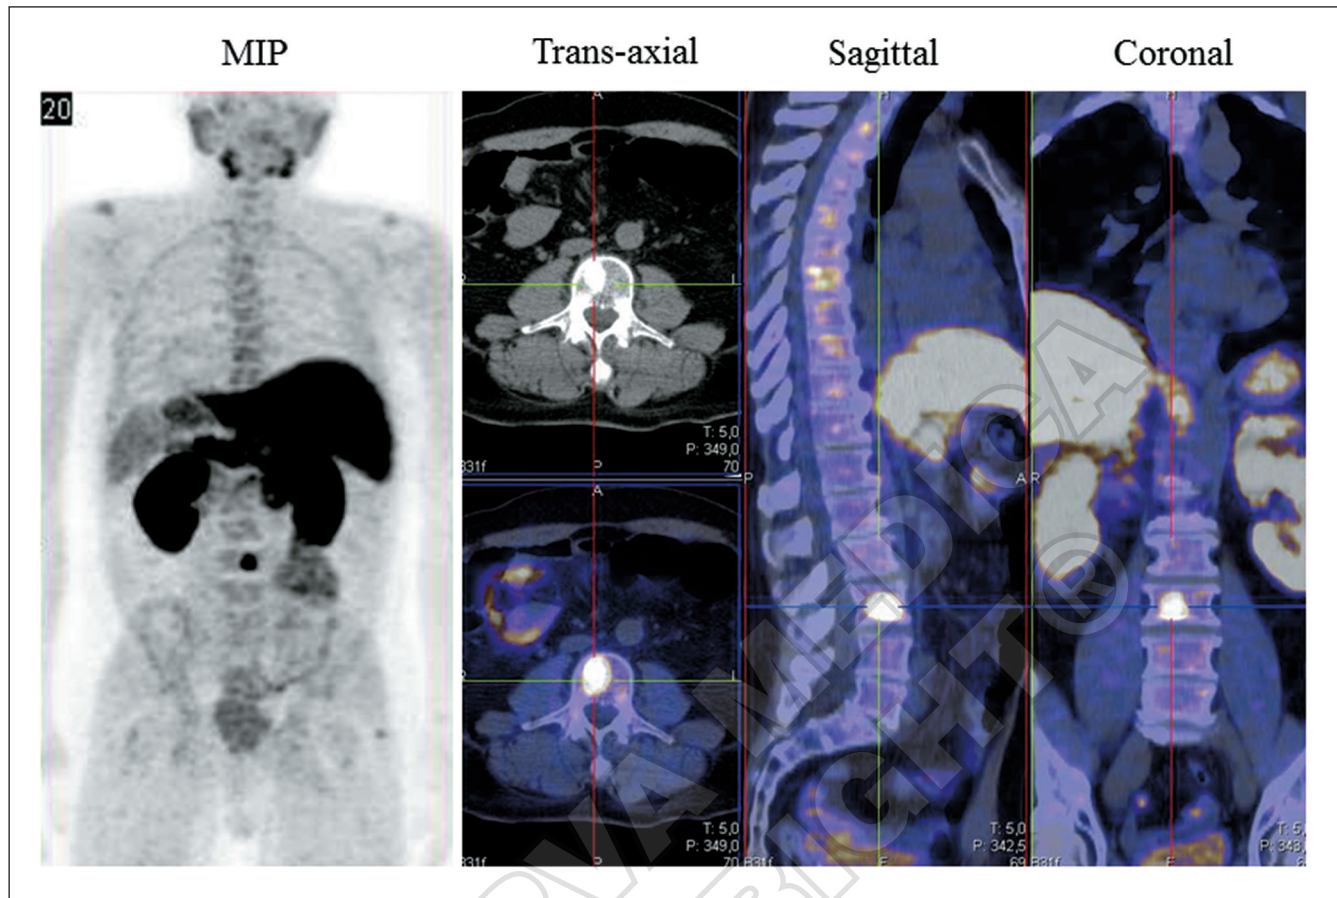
A 64-year old man with a prostate cancer (radical prostatectomy in 2008). Increase in PSA level during therapy with LH-RH analogues (0.35 ng/mL in September 2011, 0.62 ng/mL in December 2011 and 1.52 ng/mL in March 2012). In 23rd March 2012, 18F-Choline PET/CT showed a focal uptake in the lumbar vertebra corresponding to a osteoblastic lesion at CT-images.
